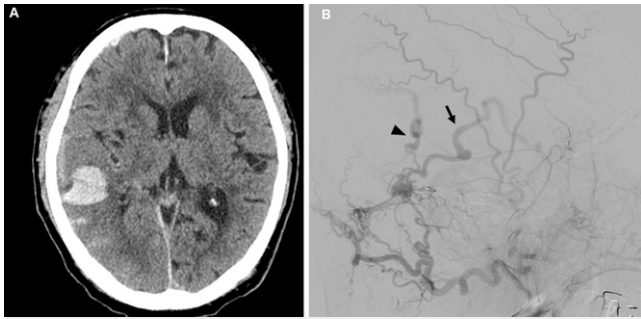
A: Brain CT performed on the day of hospitalization showing an intracerebral hematoma in the temporoparietal lobe with slight subdural hematoma and subarachnoid hemorrhage. B: Right external carotid artery angiogram showing isolated TSS-DAVF with feeding vessels from the occipital and middle meningeal arteries. The fistula drains into the vein of Labbé (arrow) and posterior parietal vein (arrowhead).
